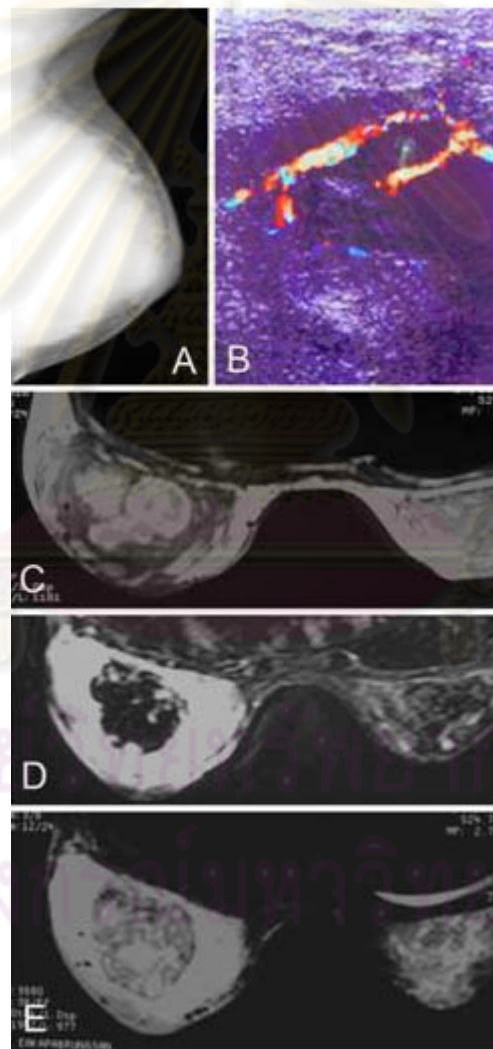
A: Mammogram MLO view showing diffuse homogeneous high density of the enlarged left breast; B: Color Doppler Sonogram showing hypoechoic mass with hypervascularity, red colour indicated vessels penetrating the mass. (Explain what red or blue color indicates); C: Axial T1 weighted-image; D: Axial T2 weighted-image revealing early subacute hemorrhage within the mass, showing high signal intensity on T1 weighted- image and low signal intensity on T2 weighted-image; E: post Gadolinium enhanced dynamic study demonstrating strong enhancement of the big mass with nonenhancing areas of hemorrhage in the central portion.
